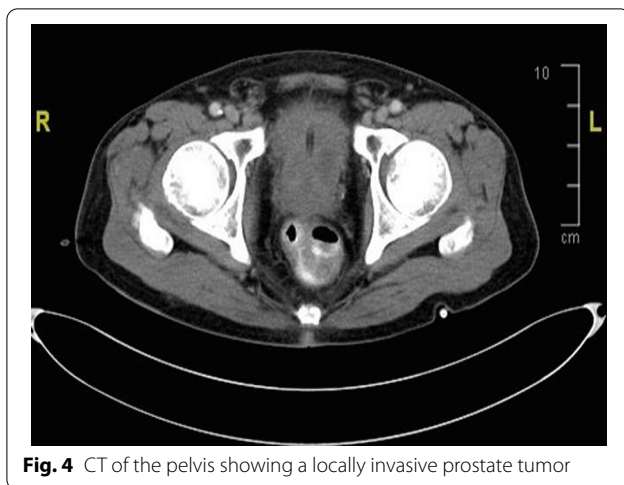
CT of the pelvis showing a locally invasive prostate tumor
